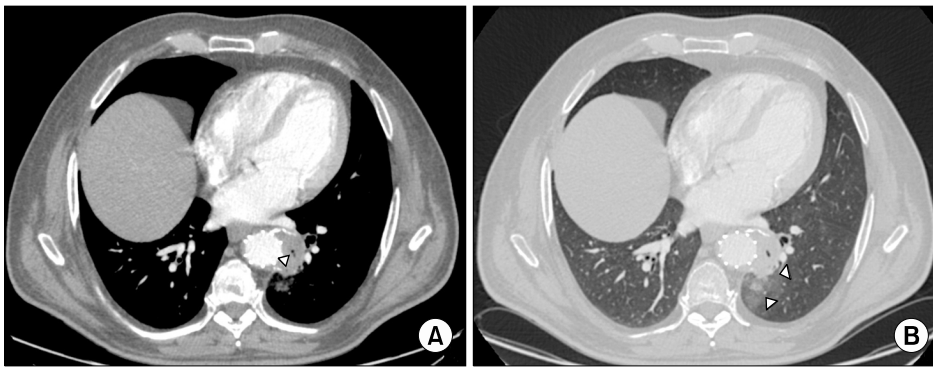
Axial contrast-enhanced multidetector computed tomography scan showing (A) an absence of endoleaks and a reduction of the air in the aneurysmal sac (arrowhead) with restoration of the wall integrity and (B) a significant reduction of atelectasis and ground glass opacities (arrowheads).
